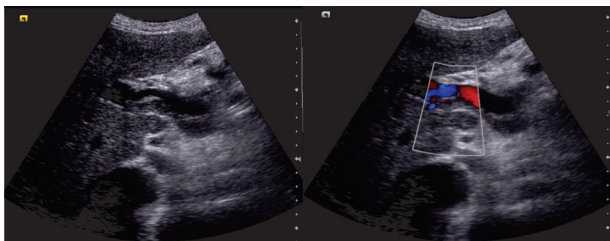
Ultrasound and color Doppler findings in patient with liver cirrhosis and portal vein thrombosis. Portal thrombosis represented by the presence of echogenic material inside the portal vein on gray-scale; flow revealed on the periphery of the vessel*
